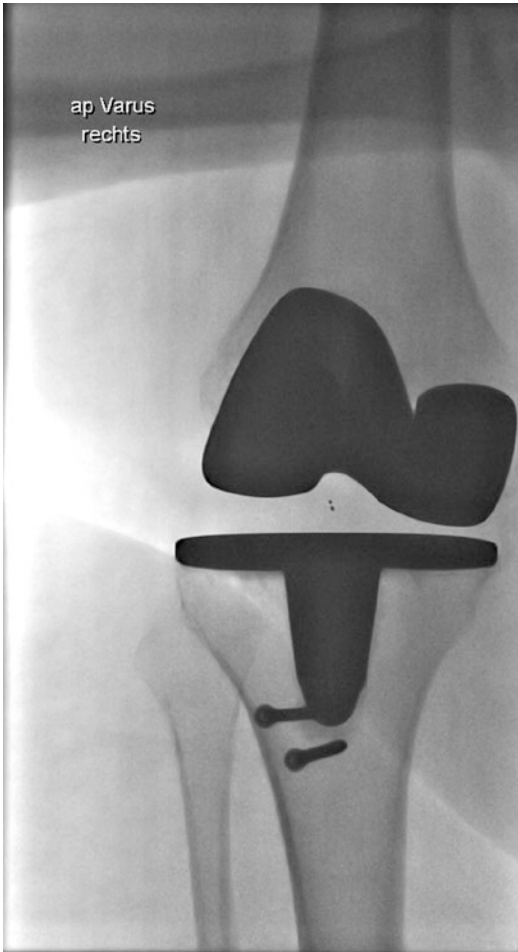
Fluoroscopic varus stress radiographs showing a lateral instability near extension
